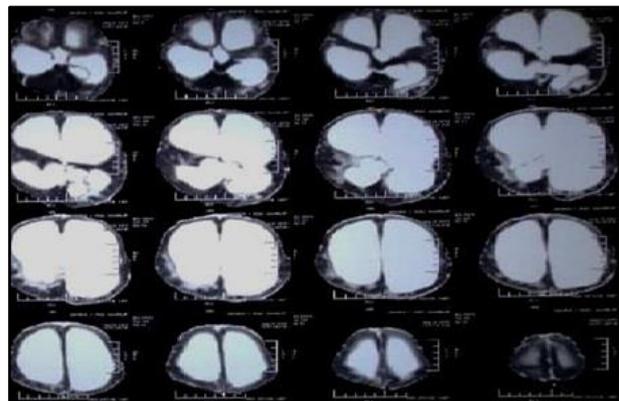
Pre-op MRI Brain T2w Image
